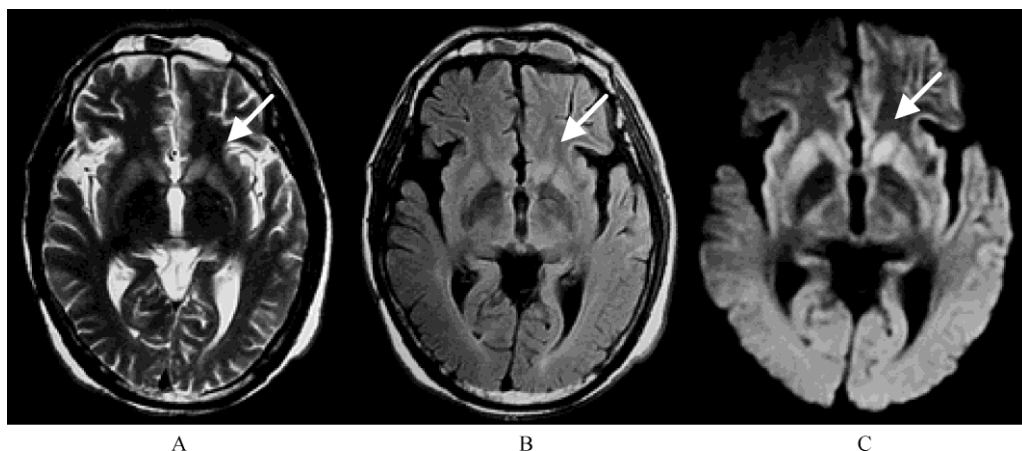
Diffusion weighted images (DWI): bilateral symmetric hyperintensive signals in the caudate putamen.
